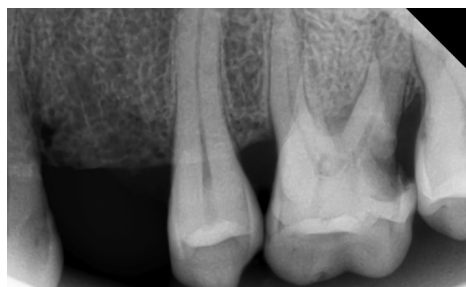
Initial Radiograph of the Left Maxillary First Molar.
